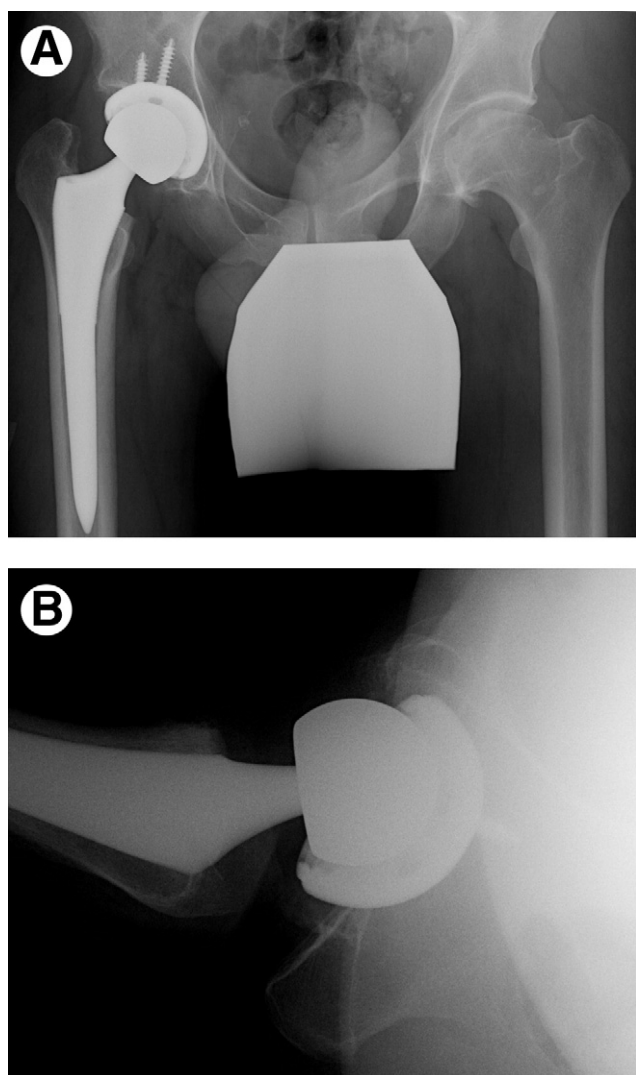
(A) This anterior-posterior (AP) radiograph of the pelvis was taken with the beam center on the pubis. The acetabular component is positioned close to the medial wall, the lateral opening angle is in the 40-45 degree range, and it is clearly anteverted. The component is well contained by the native acetabulum. The limb length and offset of the prosthetic hip is similar to that of the contralateral hip. (B) Shoot-through lateral radiograph of the hip taken as described by Danelius and Miller (1936).¹¹ The acetabular component is clearly forward facing, which reduces the potential for anterior femoral-acetabular impingement but increases the potential for posterior femoral-acetabular impingement with extension and external rotation. It is not possible to determine the amount of femoral anteversion on conventional radiographs.
